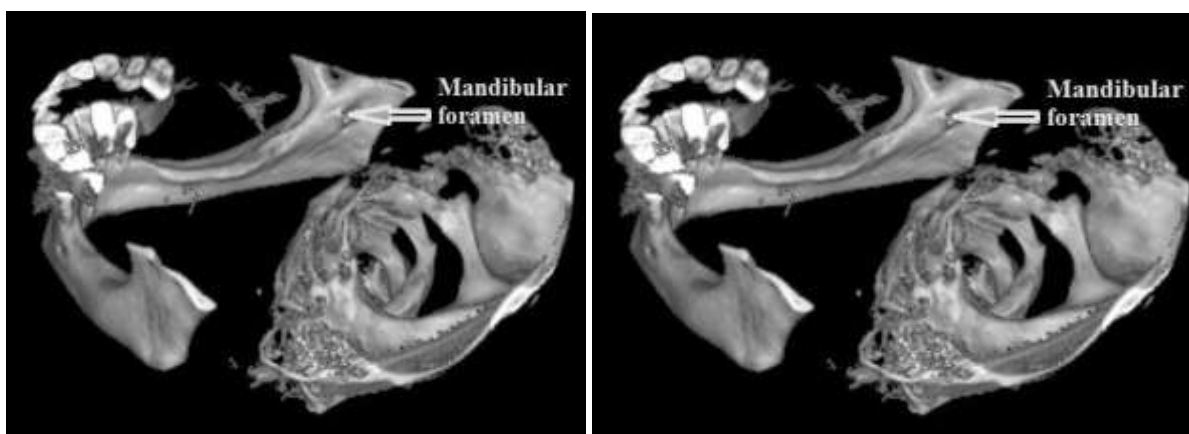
Mandibular foramen. 44 aged woman. CT reconstruction.
